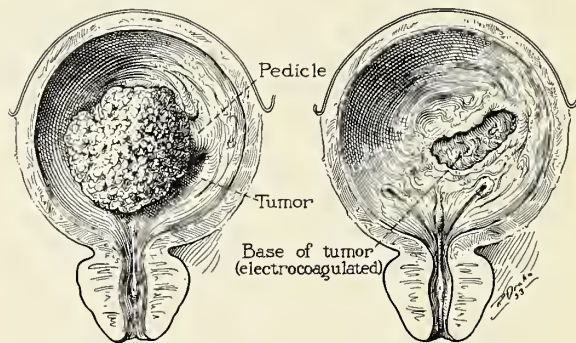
Patient aged fifty-three years. Papillary squamous cell epithelioma, graded 3. Hematuria, nocturia and dysuria had been present for one year. Excision and electrocoagulation was done. Roentgen treatment for four hours after operation. Condition good at time of dismissal.
